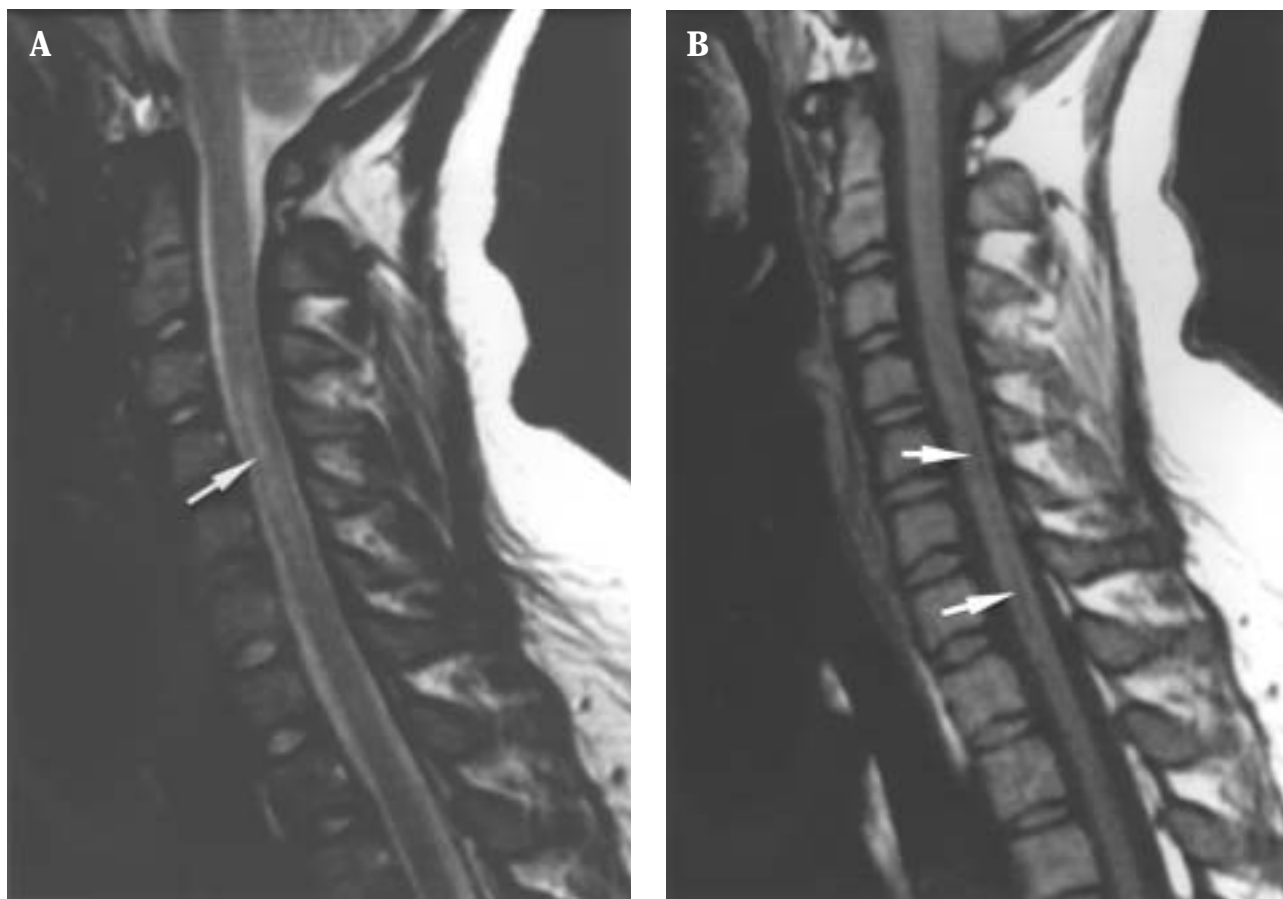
Preoperative unenhanced sagittal magnetic resonance images of the craniocervical junction and cervical spine show the dilated central canal within the cervical spinal cord (arrows): (A) T2-weighted; (B) T1-weighted.
